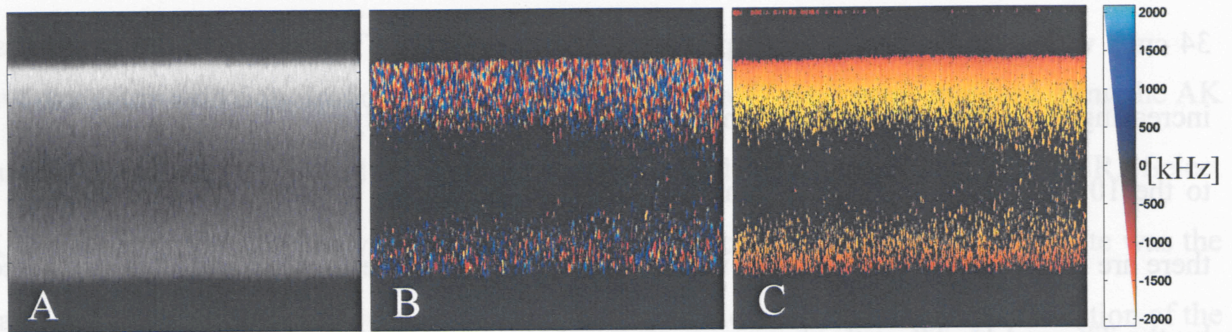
Ultrafast M-Mode flow image. A) Structural image range 6dB to 72dB. B) TK range -4 kHz to 4kHz. C) AK range 2 MHz to 2 MHz. When the Doppler shift increases to 1800 kHz that the signal begins to vanish in all three images as predicted.
